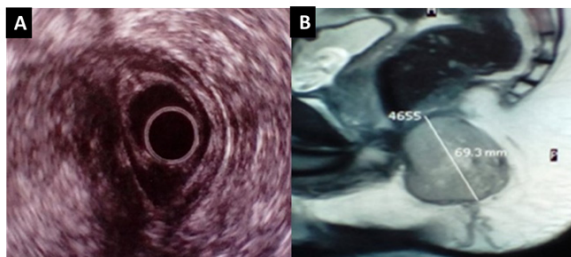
A) Transanal ultrasound showed an anal mass and B) sagittal magnetic resonance imaging showing a lobular tumor of heterogeneous signal, without central enhancement.
